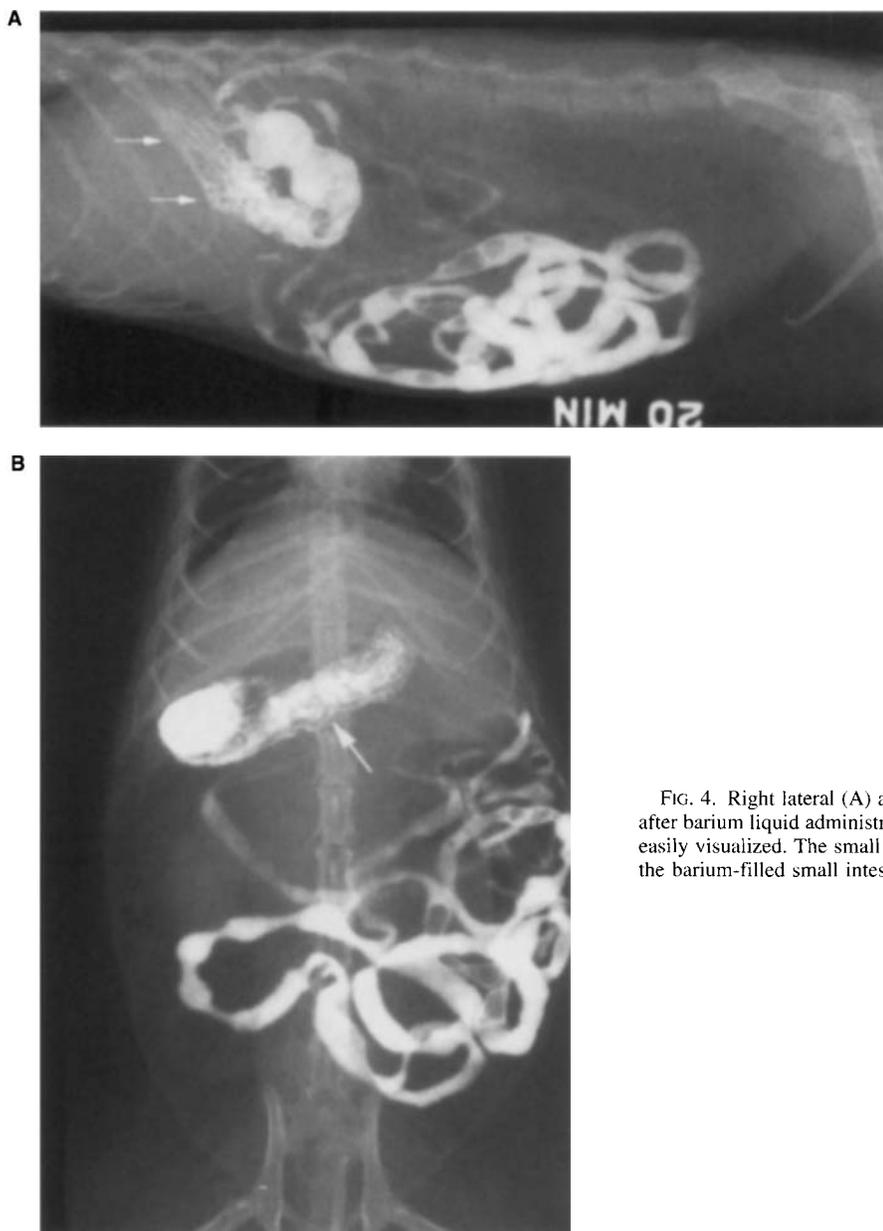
Right lateral (A) and ventrodorsal (B) radiographs obtained 20 min after barium liquid administration. The rugal folds of the stomach (arrows) are easily visualized. The small intestine is filled with barium. Maximal width of the barium-filled small intestine was 5-7 mm.
